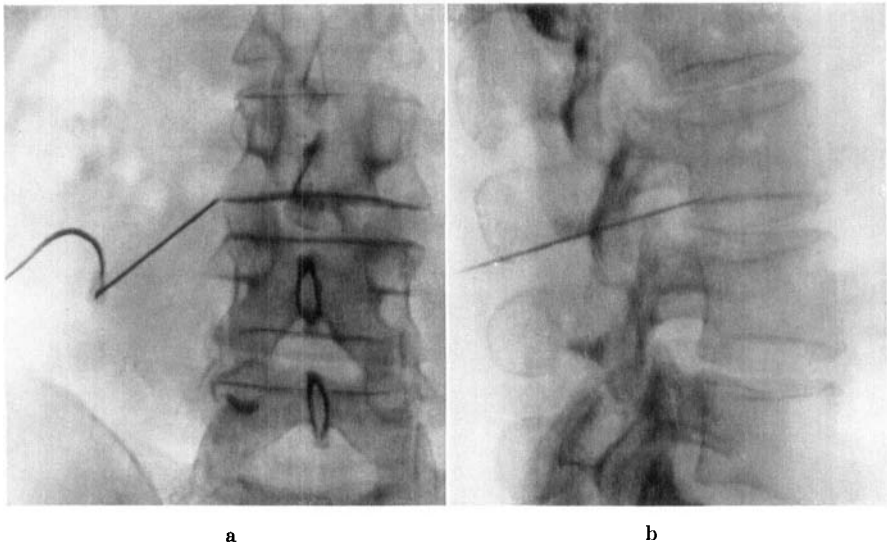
Roentgenograms of the electrode inposition.
